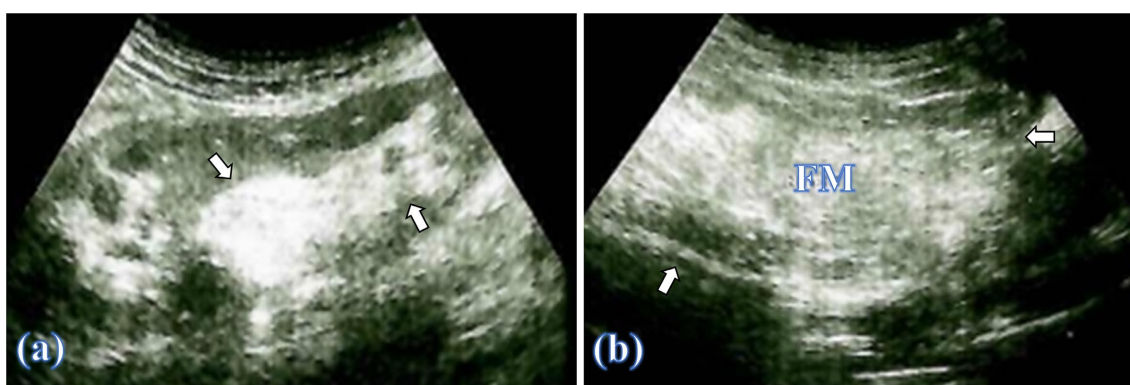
Right pelvis ultrasound picture showing: (a) a 9 cm kidney graft without hydronephrosis yet with fat in its sinus (Arrows) and (b) its surrounding pelvic fatty mass (FM) within a capsule (arrows).
